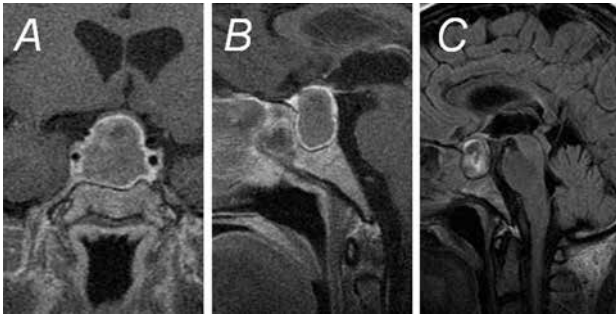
Gadolinium-enhanced T1-weighted sagittal and coronal MRI (A, B) and FLAIR sagittal (C) of the pituitary gland showing a $27 \times 24 \times 15$ mm mass indicative of infarctive pituitary apoplexy with extension toward the right cavernous sinus and upward displacement of the optic chiasm. Enlargement of the sella turcica with typical thickening of the sphenoid sinus mucosa is visible
